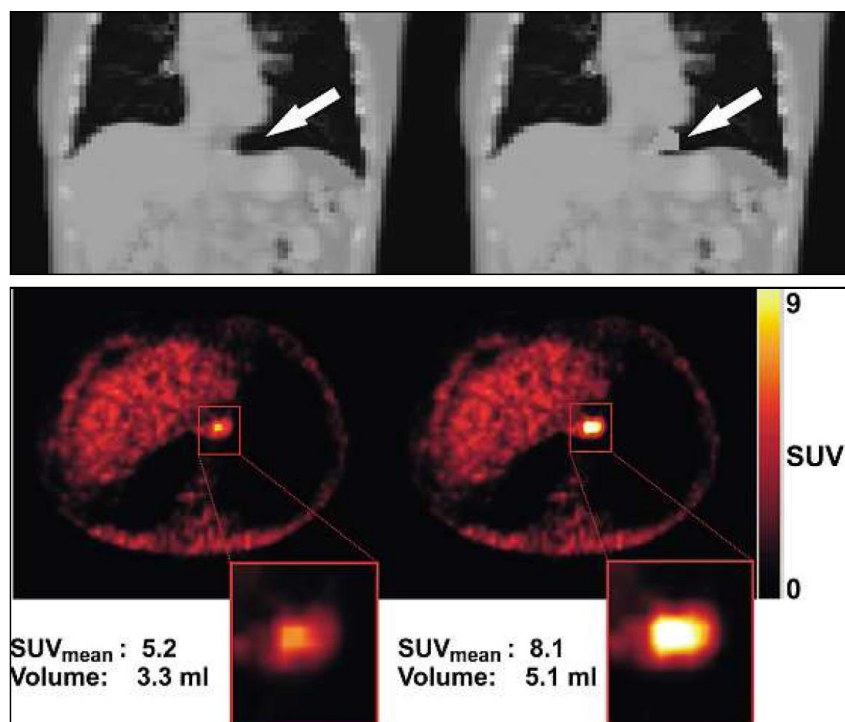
Top: CT image before (left) and after correction (right), using a similar emission-driven algorithm as for the heart. Bottom: Transaxial PET image reconstructed with the original (left) and the corrected attenuation map (right), showing a 56% increase in SUV after correction (from 5.2 to 8.1) and a 55% increase in lesion volume. Reproduced from [48] with permission from Schattauer.
